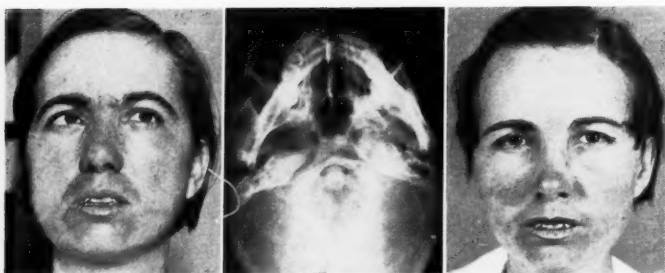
Photographs made before and after x-ray therapy and a vertical roentgenogram showing a large defect in the right middle fossa produced by a transitional carcinoma of the pharynx in Case 1. The strabismus disappeared soon after she was treated and she has remained well for almost six years.
